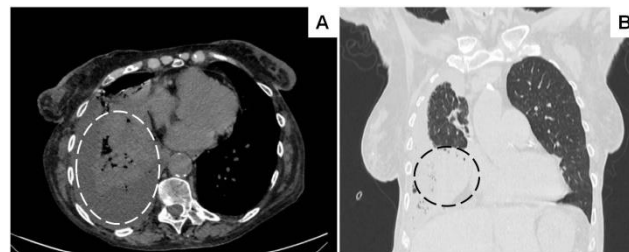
Right empyema (dotted circled area) causing compression of the lung parenchyma. (A) Contrast-enhanced CT scan transverse section, mediastinal window. (B) Contrast-enhanced CT scan, coronal section, lung window
